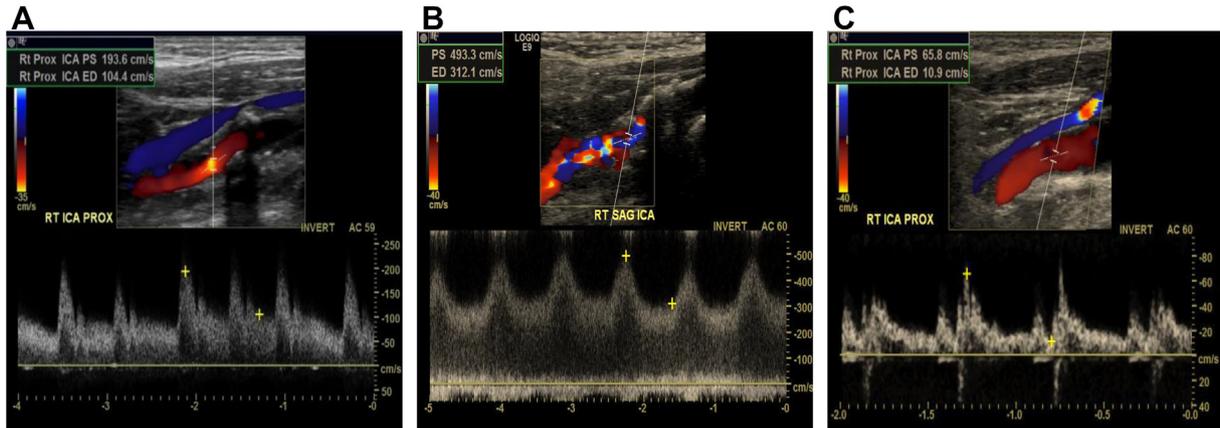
Representative images from duplex ultrasound examination of the right internal carotid artery (ICA) obtained at various time points. A, Before left ventricular assist device (LVAD) placement, duplex ultrasound shows elevated velocities consistent with moderate stenosis. *ED*, End diastole; *PS*, peak systole. B, At the time of transient ischemic attack (TIA) and before carotid endarterectomy, duplex ultrasound demonstrates high peak systolic velocity (PSV) as well as elevated end-diastolic velocity, decreased pulse pressure, and flow turbulence, indicating severe stenosis. C, After carotid endarterectomy and cardiac transplantation, duplex ultrasound demonstrates more normal flow dynamics.
